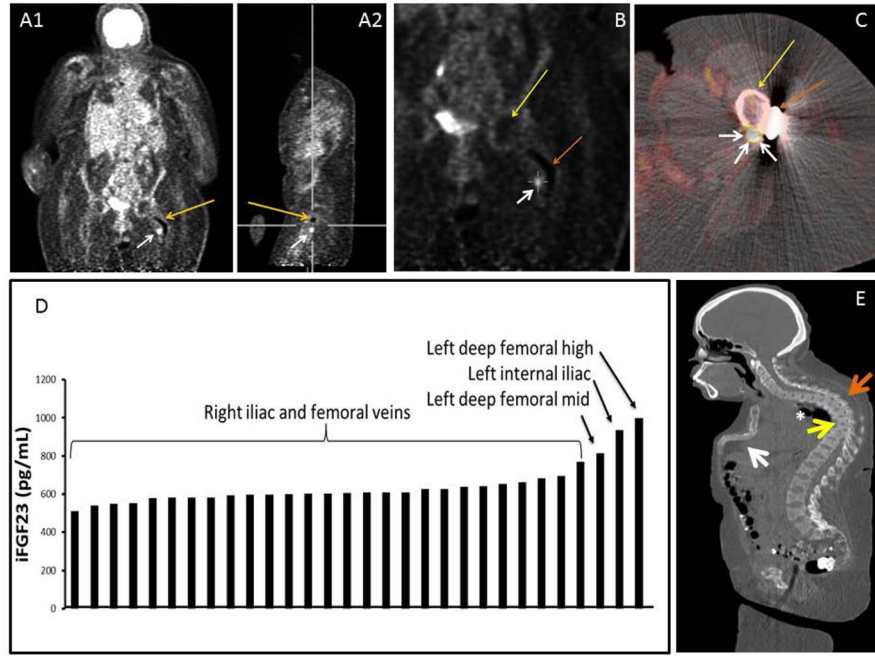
Localization studies subject 1: Panel A. FDG-PET coronal (A1) and sagittal image (A2) showing artifact from rod (orange arrow) and culprit tumor (white arrow). Panel B: Coronal view of FDG-PET scan localizing the lesion (white arrow), femoral head (yellow arrow) and rod (orange arrow). Panel c: Axial view of FDG-PET/CT fusion imaging localizing the lesion-white arrows point the tumor, yellow arrow points the femoral shaft and orange arrow points the side plate. Panel D. Selective venous sampling for intact FGF23. There was a significant step-up in FGF23 concentration as the suspected tumor venous drainage was approached anatomically. Panel E. CT-Scan sagittal view showing sternal collapse (white arrow), kyphosis (orange arrow), vertebral compression fractures (yellow arrow) and restrictive lung disease (asterisk).
